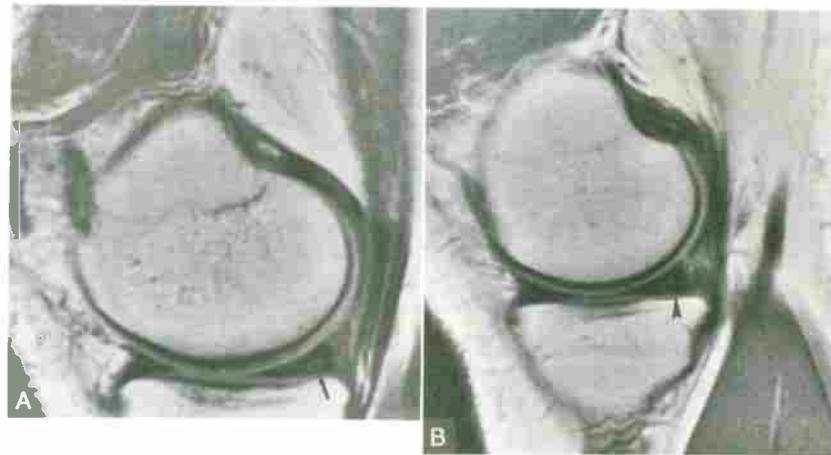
Meniscal degeneration. Sagittal T1-weighted (TR/TE, 800/20) images. A, Round area of intrameniscal high signal intensity (arrow) due to mucoid degeneration. B, A different patient with linear grade 2 signal (arrowhead) again not traversing the articular surface.
